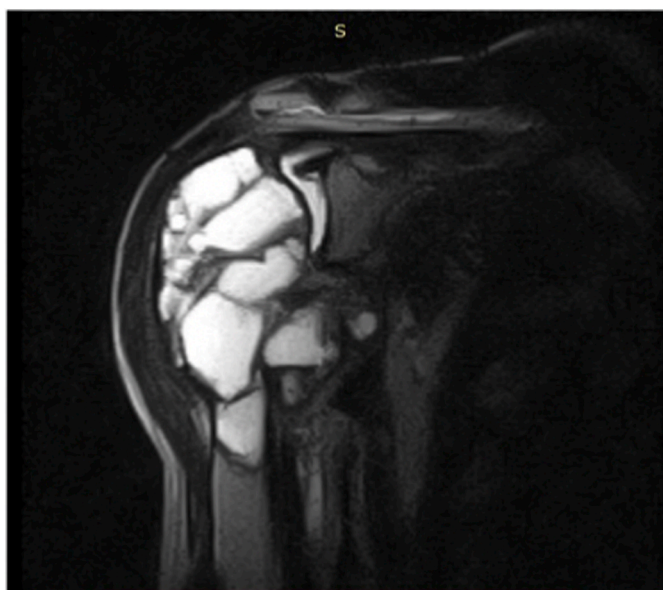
The tumor invading parts of the rotator cuff tendon, the inferior margin of the tumor has not invaded the deltoid tuberosity on MRI.
